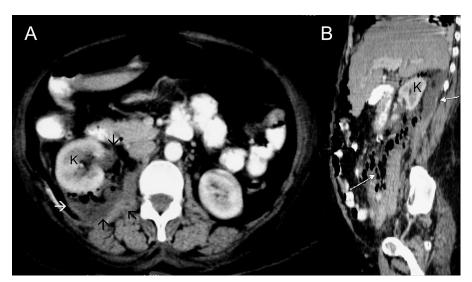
Postoperative computed tomographic scan (A = axial section, B = sagittal section): arrows showing a retroperitoneal collection of fluid and air displacing the right kidney (K).
